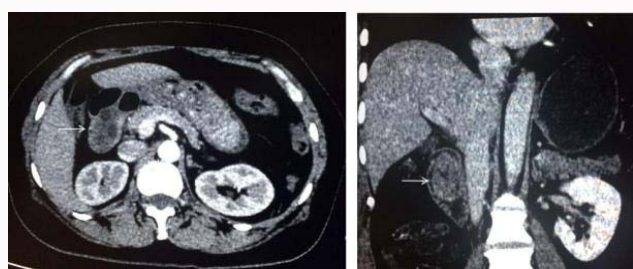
Abdominal CT revealed a round mass with internal multifocal low densities in the proximal duodenum (arrow).
